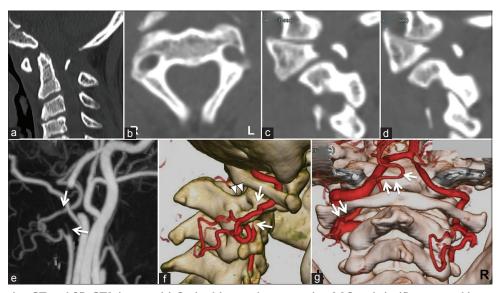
Preoperative CT and 3D-CTA images. (a) Sagittal image demonstrating AAS and significant atrophic posterior arch of the axis. (b-d) CT mages demonstrating hypoplasia of the right (c) and left (d) C2 pedicles and the rather thin C2 lamina. (e and f) 3D-CTA images showing complete regional occlusion of the right VA at the C2 transverse foramen with collateral flow (arrows indicating occlusion borders) and hypoplasia of the right C2 pedicles (arrowheads). (g) 3D-CTA image showing the laterality of the VAs and the left C2 origin of the PICA (arrows)
